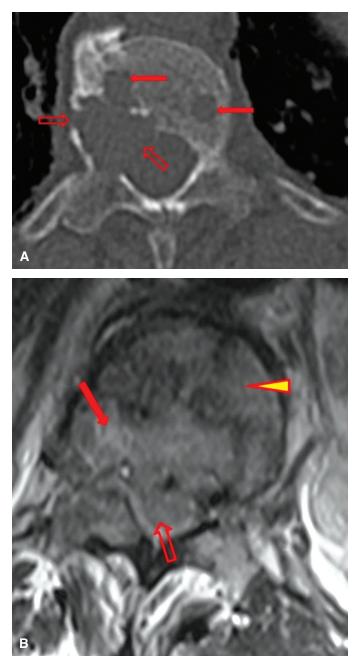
Vertebral body metastasis. *A*: Axial, CT scan of T12 thoracic vertebra shows lytic lesions of soft tissue attenuation (*closed arrows*), with irregular margins, and breaching the cortex (*open arrows*). *B*: Axial, T2W MR image through T12 vertebra of the same patient shows intermediate intensity lesion (*closed arrow*) with posterior extraosseous extension, encroachment on the anterior epidural space, and ventral compression on the spinal cord (*open arrow*). This detail is not appreciated on the CT scan. *Arrowhead* identifies the normal marrow space.
